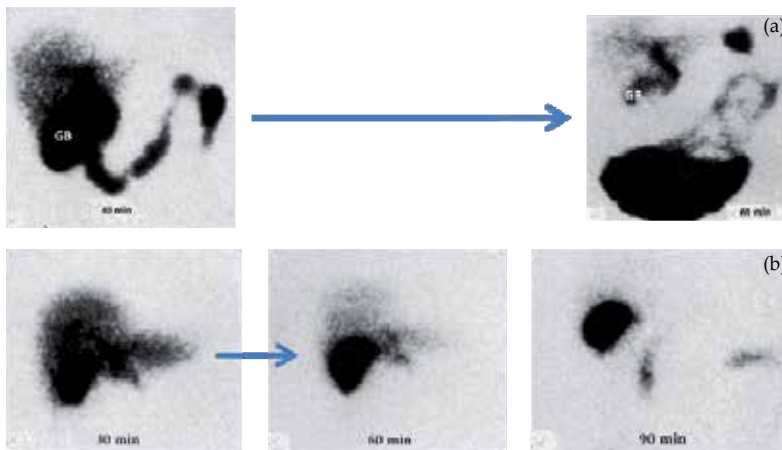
A. Normal gallbladder emptying on CCK-cholescintigraphy. The gallbladder is visualized 30 minutes after the injection of the 99m -labelled technetium iminodiacetic acid radiopharmaceutical (HIDA scan). Cholecystikinin is then infused (shown as arrow). Prompt gallbladder emptying (70% here) then ensues with the radiolabel ejected into the small intestine. The gallbladder is depicted as GB, before and after the CCK infusion. [52], B. Abnormal gallbladder emptying. Although the gallbladder fills, becoming well visualized at 30 minutes, the CCK infusion (arrow) has little effect thirty minutes later at 60 minutes into the study or even with an additional thirty minutes at 90 minutes. The liver washes out during this period of time. [52]
